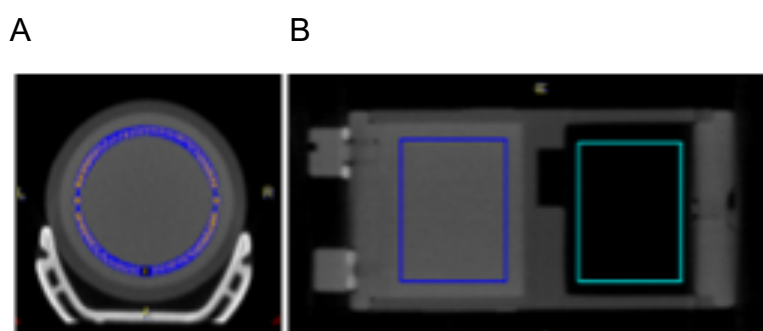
PMOD screen shot showing the VOI placement on the CT water and air region for HU measurements. Panel (A) provide an axial view point and panel (B) displays a coronal view showing the water (left) and air (right) chambers.
